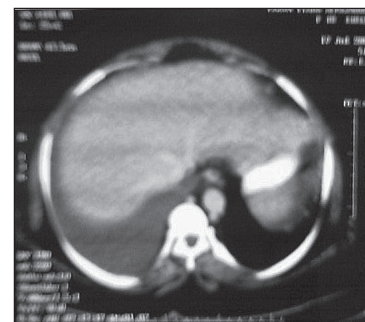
Abdominal CT scan showing ascites.
